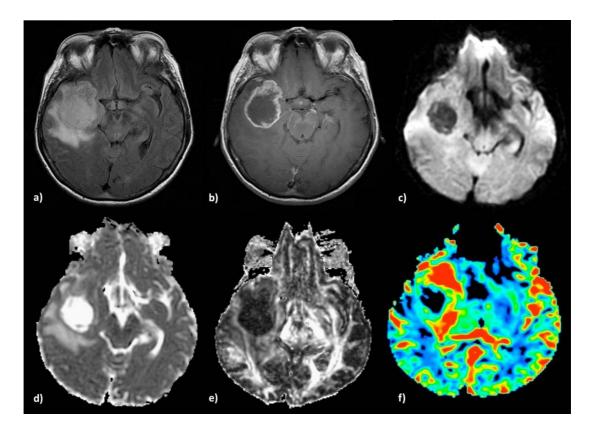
Glioblastoma imaging in a 65-years old women. Axial T2-weighted (a) and T1-weighted post-contrast (b), demonstrating a right temporal lesion with surrounding edema and ring-shaped enhancement. Diffusion weighted images with low signal intensity (c), higher intratumoral apparent diffusion coefficient (ADC) (d), lower-intratumoral fractional anisotropy (FA) (e) and high peritumoral residual cancer burden (RCB) (f), which shows tumor infiltration in the surrounding parenchyma (Image as originally published in Svolos *et al.,* 2014. License: BioMed Central Ltd. 2014).
